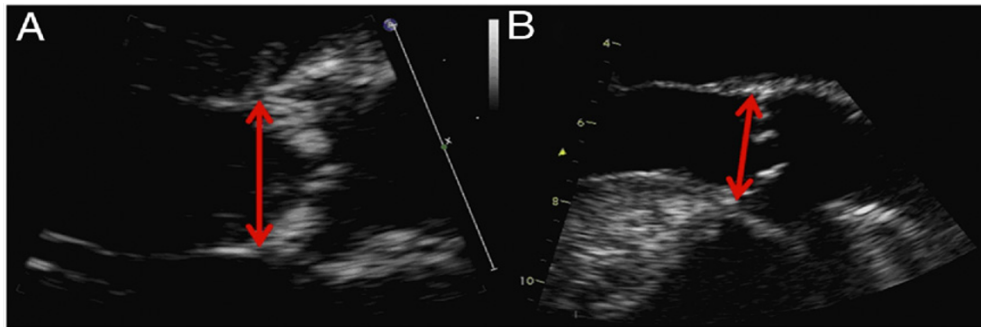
Examples of measurements of the annulus diameter by a) transthoracic echocardiography and b) transesophageal echocardiography [48].
